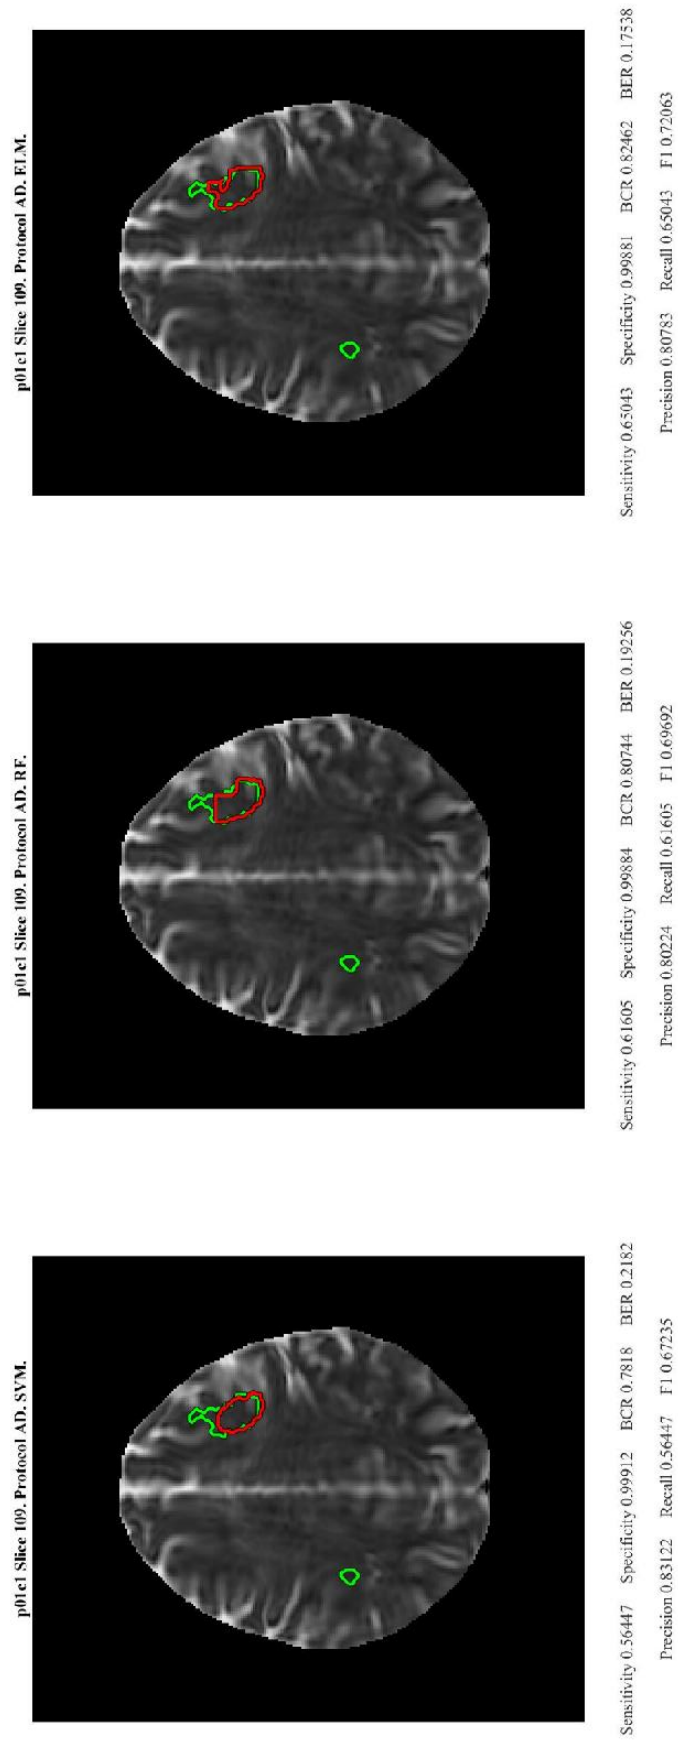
Segmentations using all machine learning classifiers trained on AD MRI sequence and features selected using LASSO feature selection for MS identification of dataset p01c1 AD sequence on slice 109.
